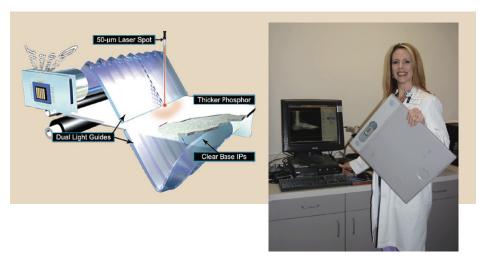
Computed radiography imaging plate prepared for insertion into electronic reader. (Courtesy Melanie Hail, Lone Star College System and Fuji Medical Systems.)
